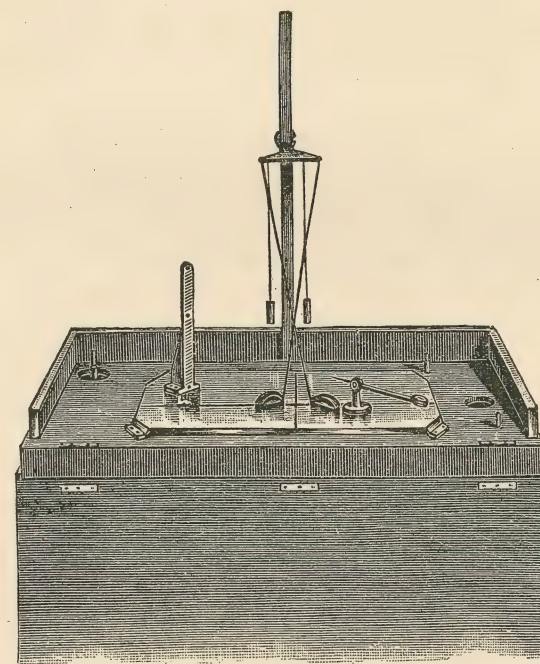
A modification of the cross-thread device for readily finding the depth of any foreign body in the tissues after making the preliminary double radiograph. It is designed for portability. See Plate No. 76 for picture of the finer original apparatus.
